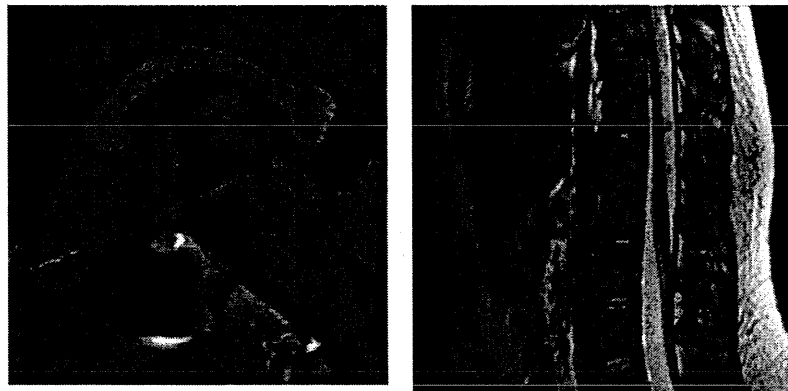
Brain magnetic resonance imaging of the deletion-positive patient
